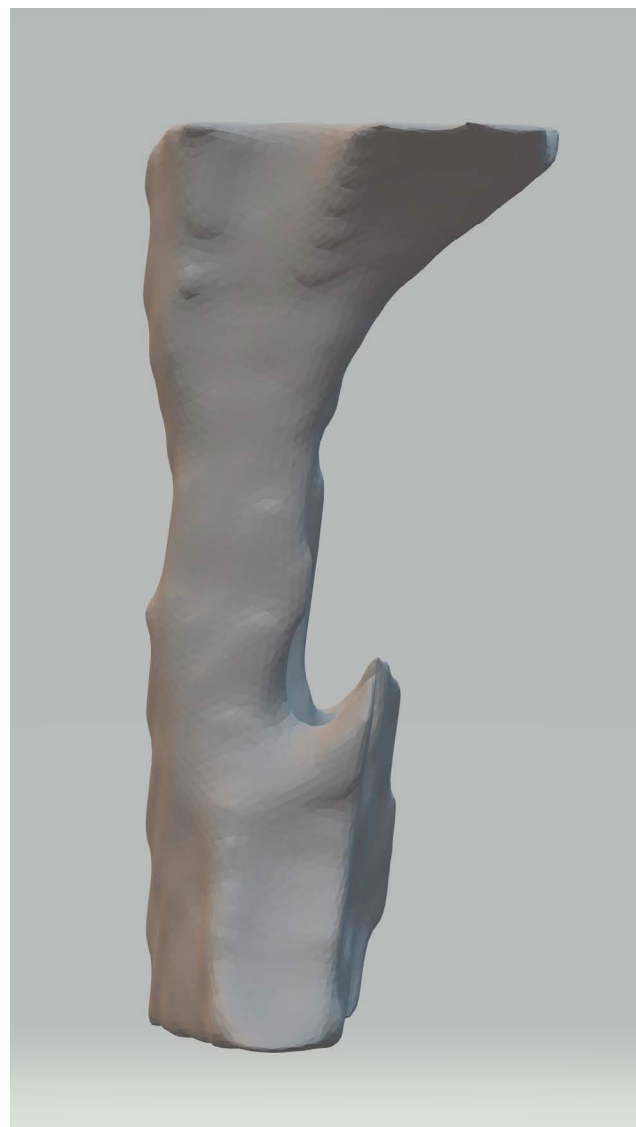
A cone-beam computed tomographic scan displays an automated 3-dimensional segmentation of the oropharyngeal airway volume. The segmentation, generated by InVivo5 software (Anatomage, San Jose, CA, USA), extends from the level of the posterior nasal spine to the level of the most anterior inferior point of the second cervical vertebrae.
